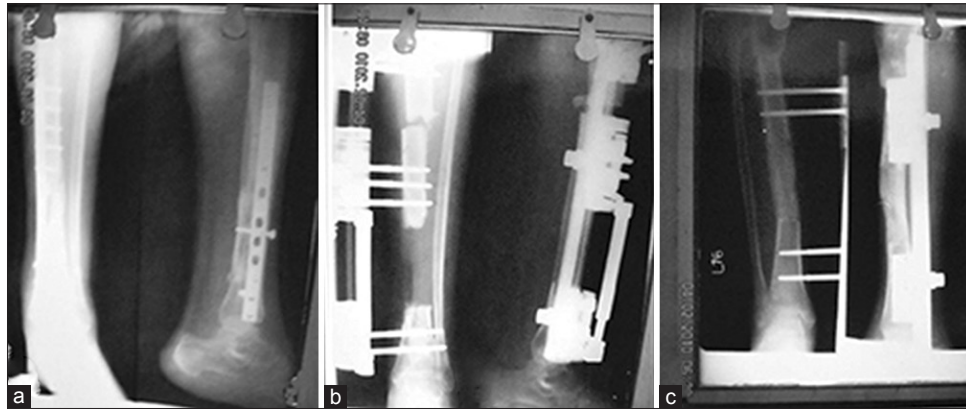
X-ray of leg bones with ankle joint showing (a) Tibia with infected implant *in situ* (b) Tibia postoperative with rail fixator and corticotomy (c) Tibia showing regenerate consolidation and docking
